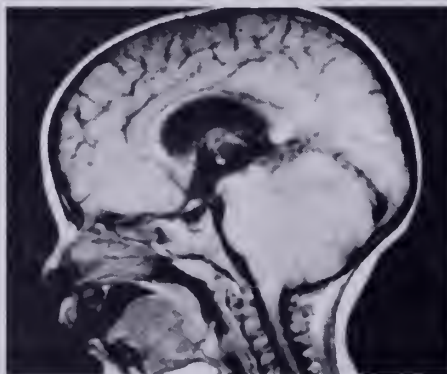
Sagittal MRI image of pituitary tumor.
